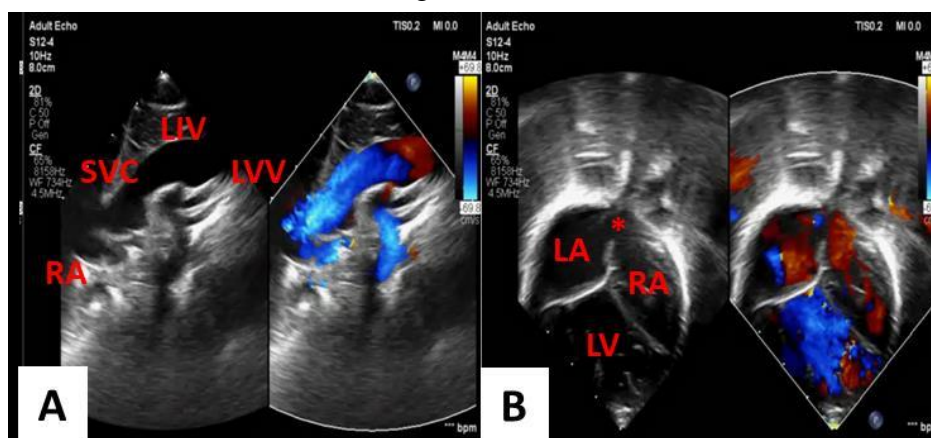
Transthoracic echocardiography results in patient that showed supracardiac TAPVR with connection in left innominate vein (LIV) (A). There was also right to left shunt as ASD in Picture B
